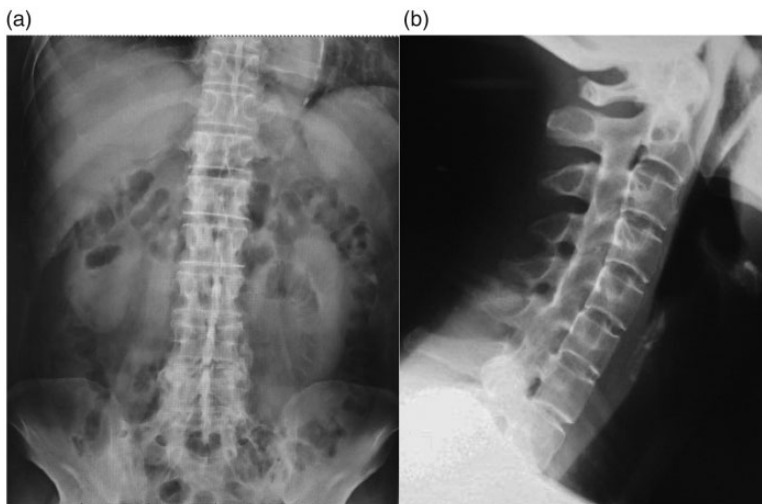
Plain radiographs of the cervical and lumbar spine. (a) Bone erosion and osteosclerosis are observed surrounding the sacroiliac joint. (b) Squaring of the vertebral bodies and ossification of the ligamentum flavum are observed on the radiographs of the lumbar and cervical spine.
